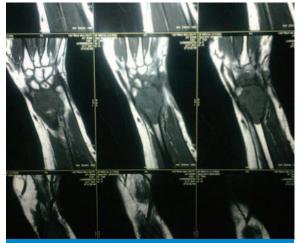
MRI-left wrist showing Expansile Lytic lesion in the distal end of radius.
